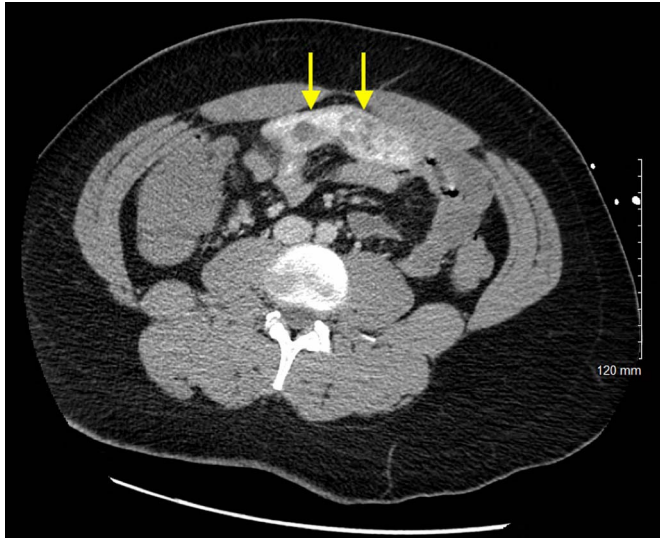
Abdominal computed tomography angiography with intravenous contrast showing intraluminal extravasation of the contrast suspected in proximal ileum or distal jejunum.
